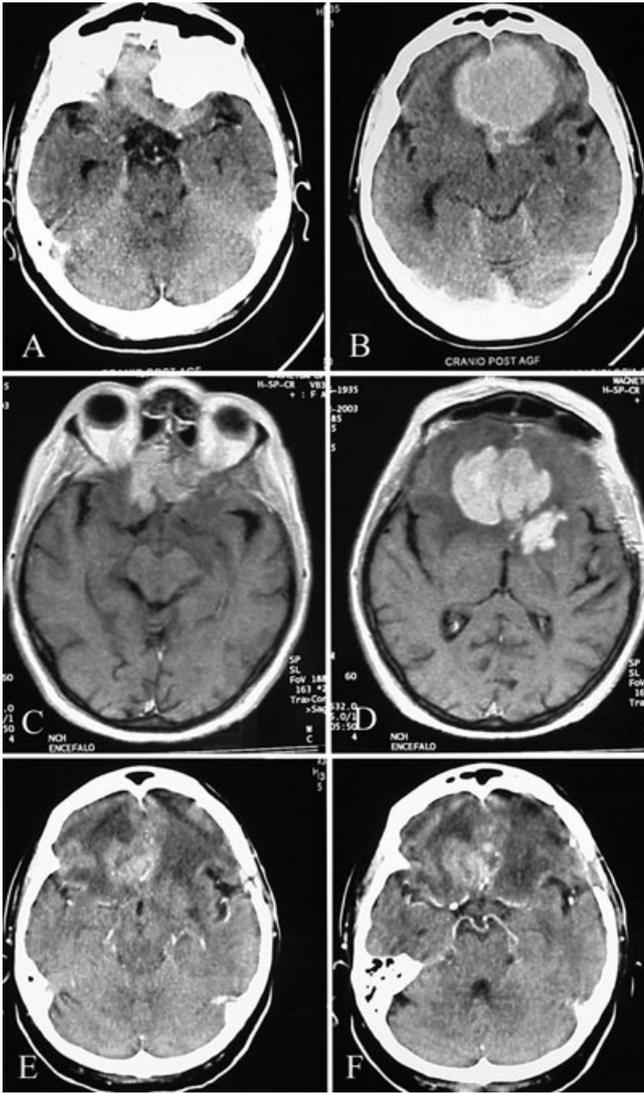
(A,B) Meningioma, CT with administration of contrast medium. Mid-line 4 cm lesion of the fronto-basal region showing two small infiltration-like areas. (C,D) Lymphoma, MRI with administration of contrast medium. A bigger lesion at the cerebral falx level and a smaller lesion in the left capsular area showing a more intense contrast enhancement. (E,F) Control during steroid and chemo therapy, CT with administration of contrast medium; reduction of the lesions is appreciable.
